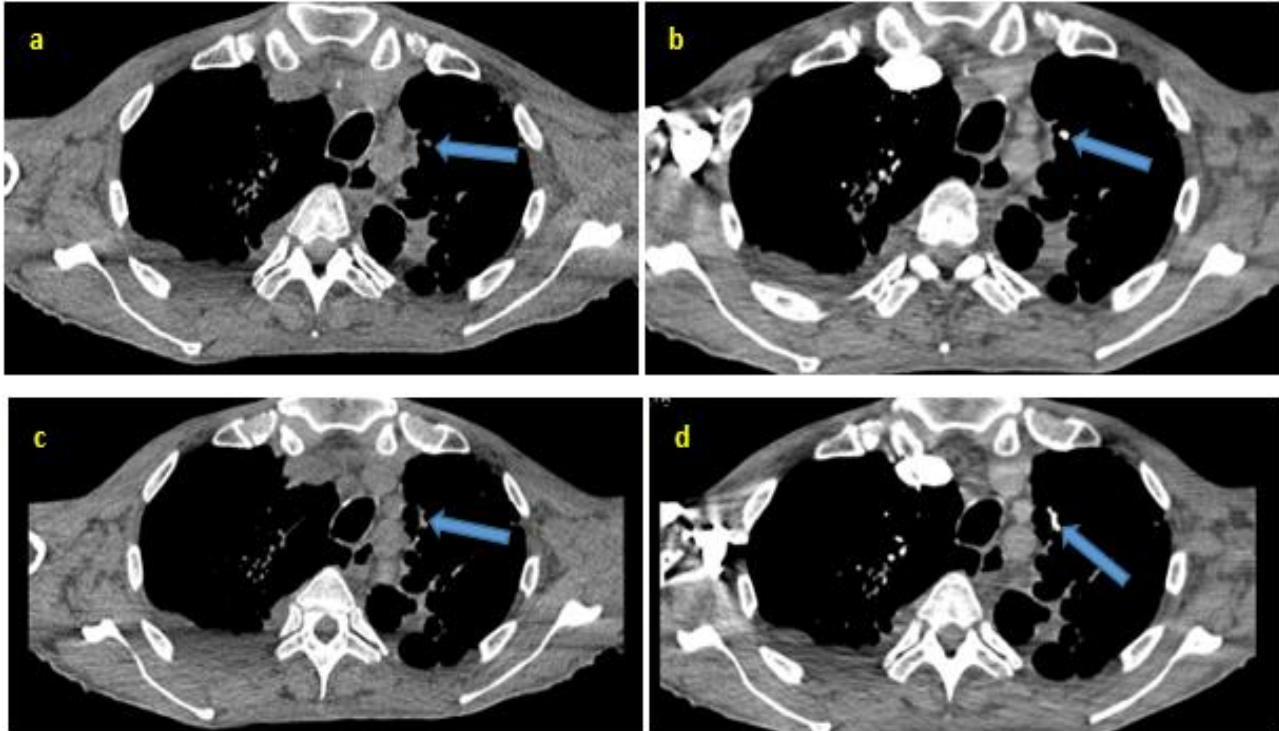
CT pulmonary angiography Mediastinal window without (a, c) and with intravenous contrast (b, d, e, f) showing a small saccular aneurysmal dilatation arising from an apical segmental branch of the left pulmonary artery demonstrating contrast enhancement synchronous with the pulmonary arterial phase (arrow), consistent with a Rasmussen's aneurysm
